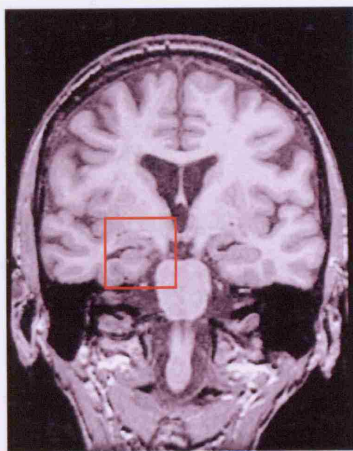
A T1-weighted scan showing hippocampal atrophy on the right in a patient with mesial temporal sclerosis. Adapted from: Cascino (2001)
